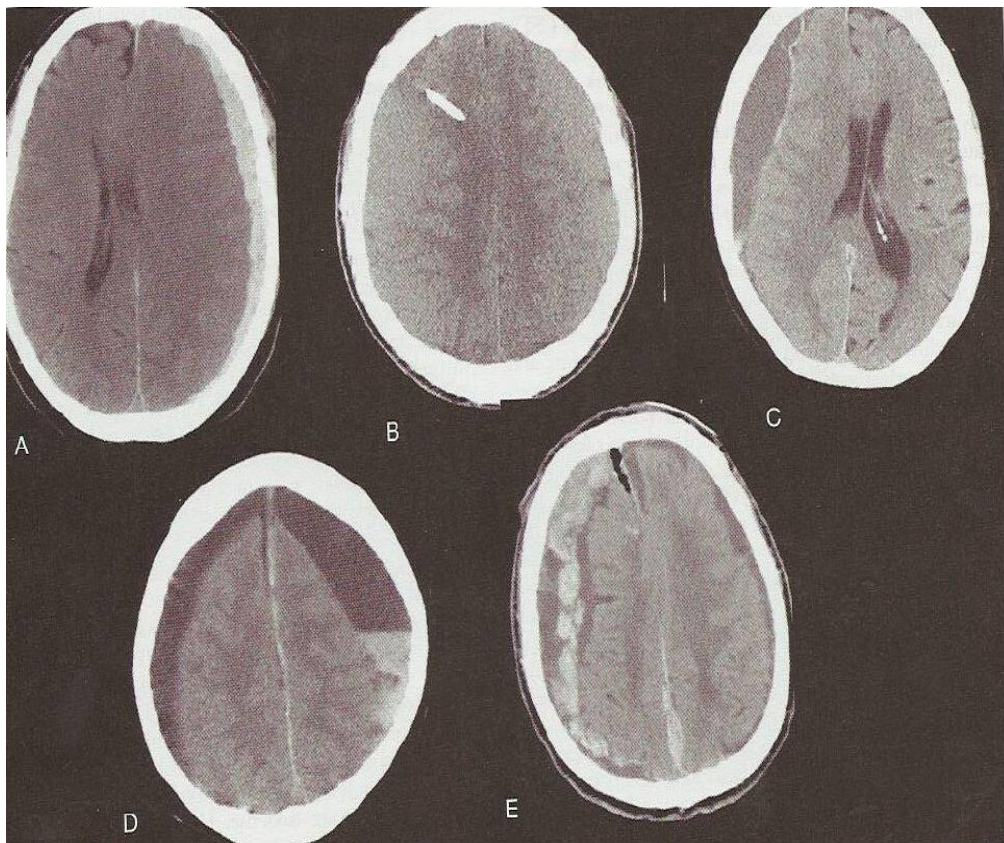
CT Scan findings as outlined by Normura *et al.*³⁴
